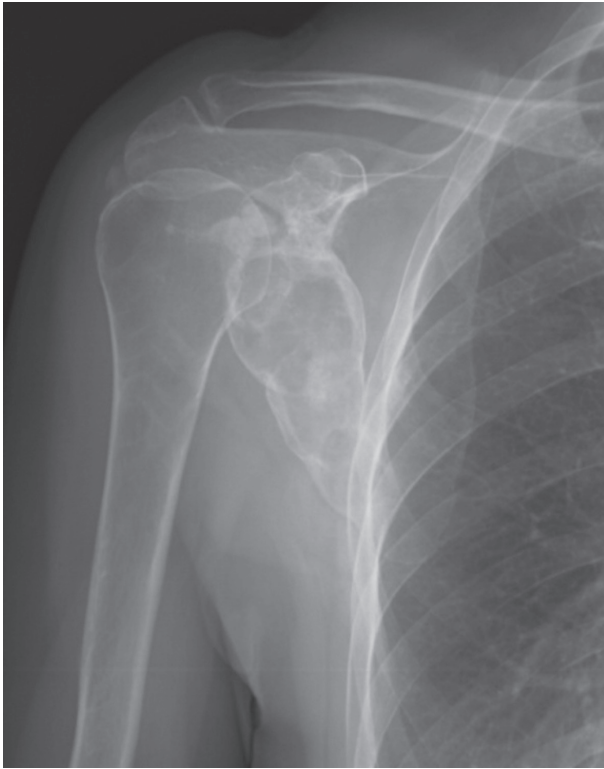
Radiograph shows an osteolytic lesion of the scapula with calcifications
